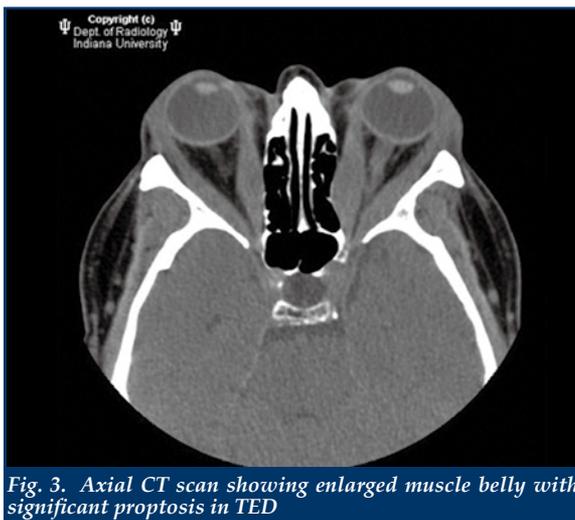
Axial CT scan showing enlarged muscle belly with significant proptosis in TED
